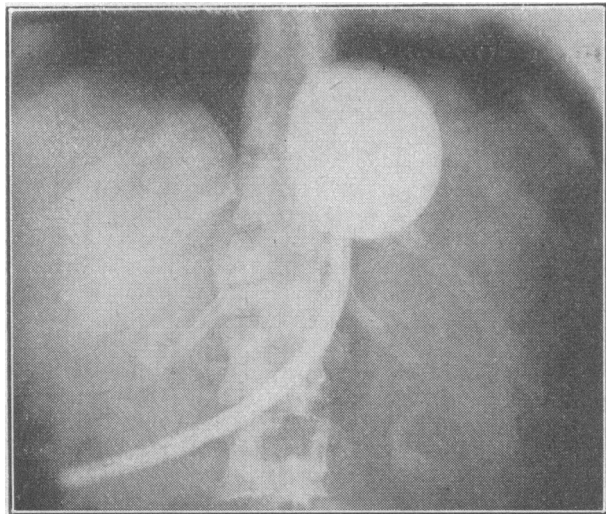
Plain x-ray film of abdomen showing the Sengstaken tube in good position. The gastric balloon is distended with 10% diodone solution.
